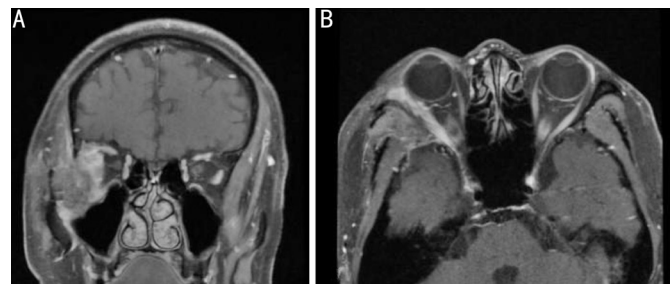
The MRI images showed a lesion within the right orbit with involvement at the temporal fossa (A) extending from the lacrimal gland area to the orbital apex (B).
